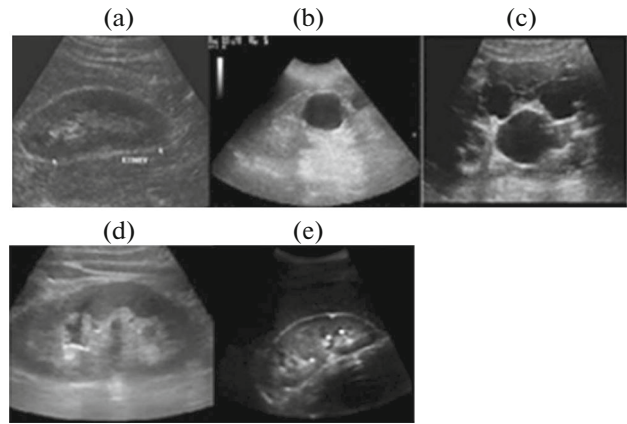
Sample kidney ultrasound images: (a) normal kidney ultrasound image, (b) single cystic kidney ultrasound image, (c) polycystic kidney ultrasound image, (d) single stone kidney ultrasound image, and (e) multiple stone kidney ultrasound image.
